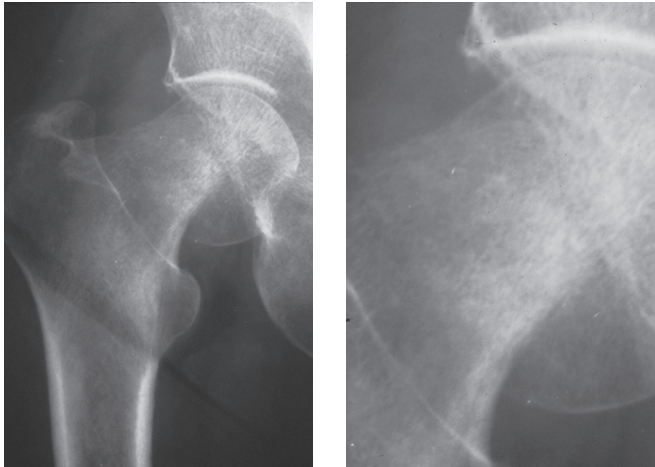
Radiographs of osteomalacic hip fractures. Hip fractures in osteomalacic bone may resemble slipped femoral capital epiphyses. They may present with chronic rather than acute bone pain, and deformity may progress over time.
